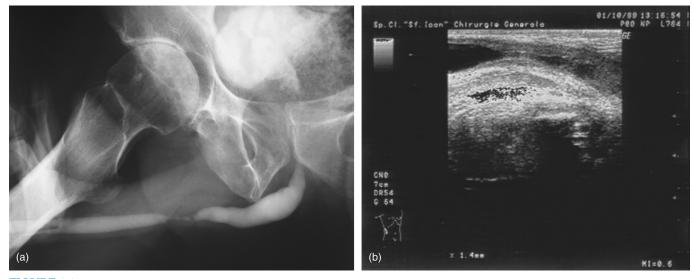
Multiple strictures of the penile urethra (a), with spongiofibrosis seen on ultrasound at 12 o'clock (b).
